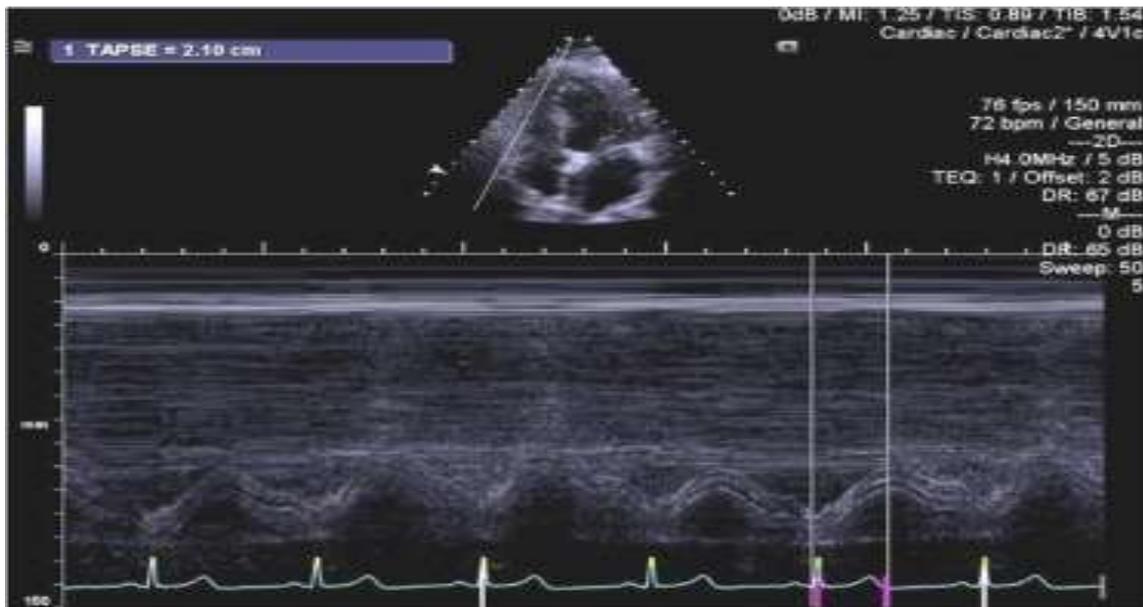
Measurement of Tricuspid annular movement by M-mode in apical 4 chamber view; normal excursion in a patient of IWMI without RVMI.
